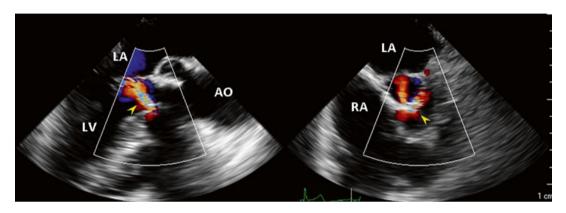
Two-dimensional transesophageal echocardiography (2D TEE) color Doppler, x-plane view, status post tissue AV replacement, showed an aorta-to-LV fistula with moderate amount shunts (*arrows*)
